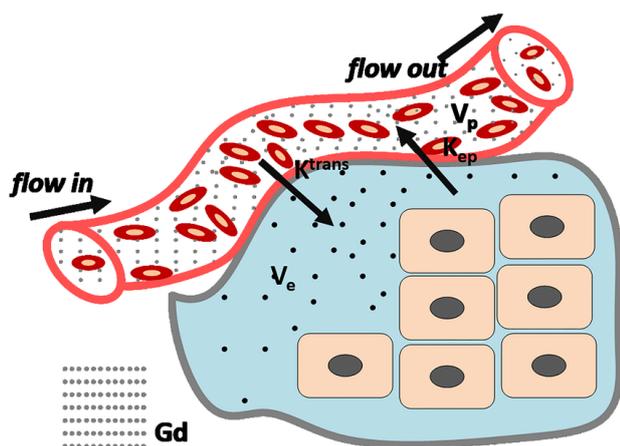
Physiological depiction of quantitative parameters of DCE-MRI from the Kety/Tofts model. The grey dots represent gadolinium. This is present in the blood vessels next to the red blood cells. The blood and contrast agent flow in and out of the vessel. While the blood flows from one side to the other, the contrast agent can diffuse into the extravascular extracellular space (EES). This is quantified with K_{trans} . V_e signified the portion of contrast agent in the EES and V_p in the blood vessel. K_{ep} indicates the movement of gadolinium from the EES back to the blood vessel (Yan, Sun, and Shen, 2017).
